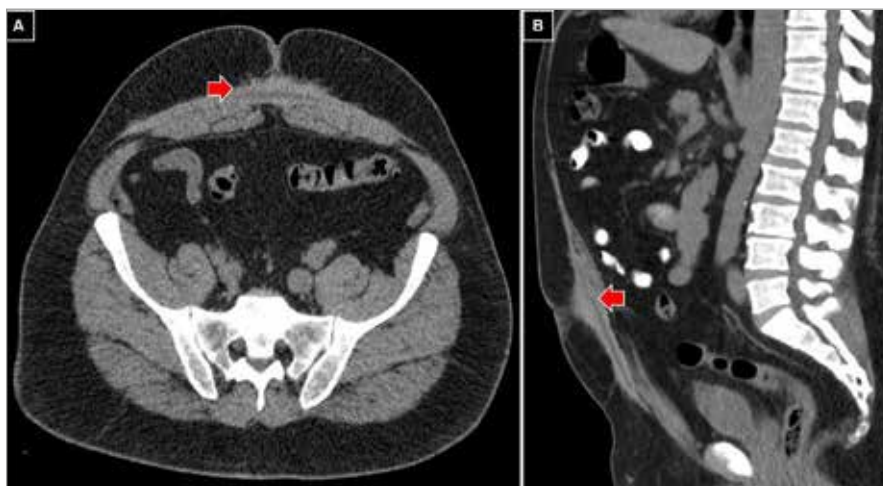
Control 2 years after sclerotherapy. Computed tomography of the abdomen and pelvis shows fibrosis in the subcutaneous plane with resolution of the seroma (red arrow).
